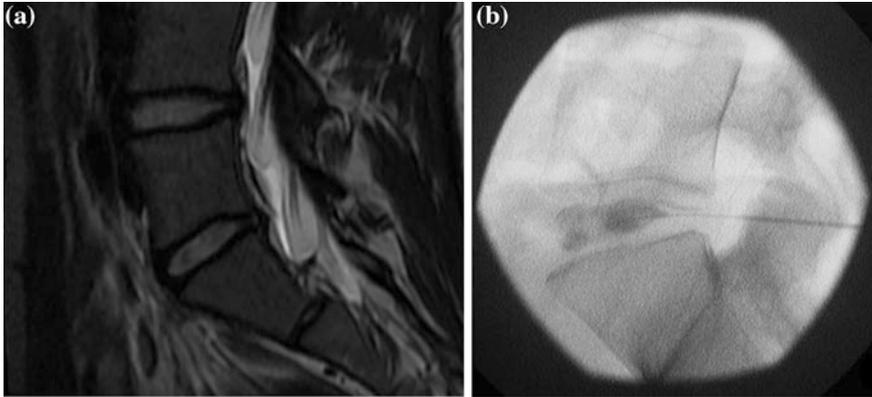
Case #5 a Faint high-intensity zone at posterior annulus of L5-S1, T2 MRI. b Discogram with a faint line of contrast extending posteriorly from the nucleus pulposus revealing a tear of the annulus fibrosus
